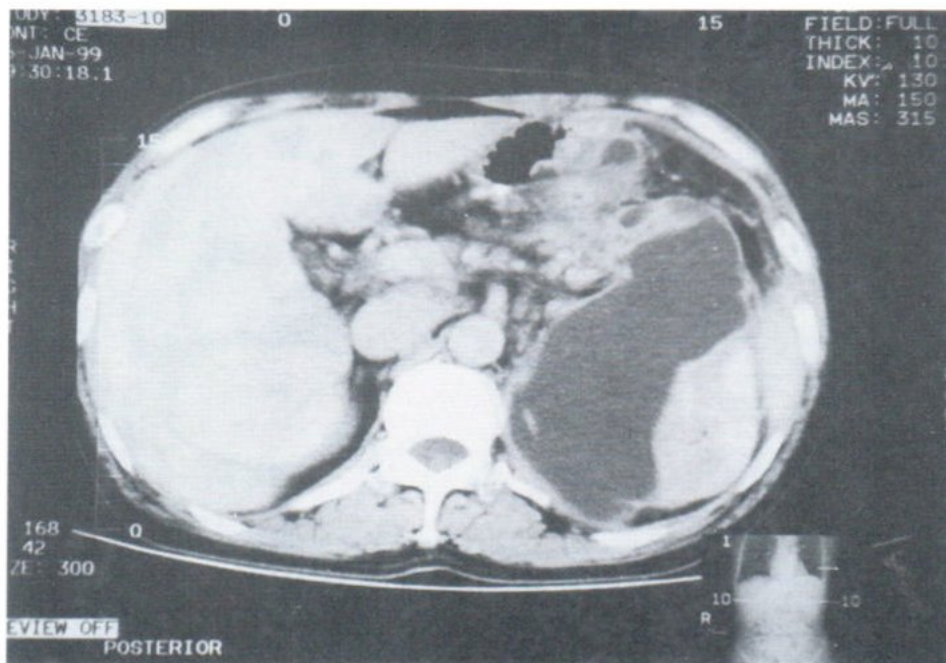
CT scan showed subcapsular pseudocyst at the upper pole of left kidney.
